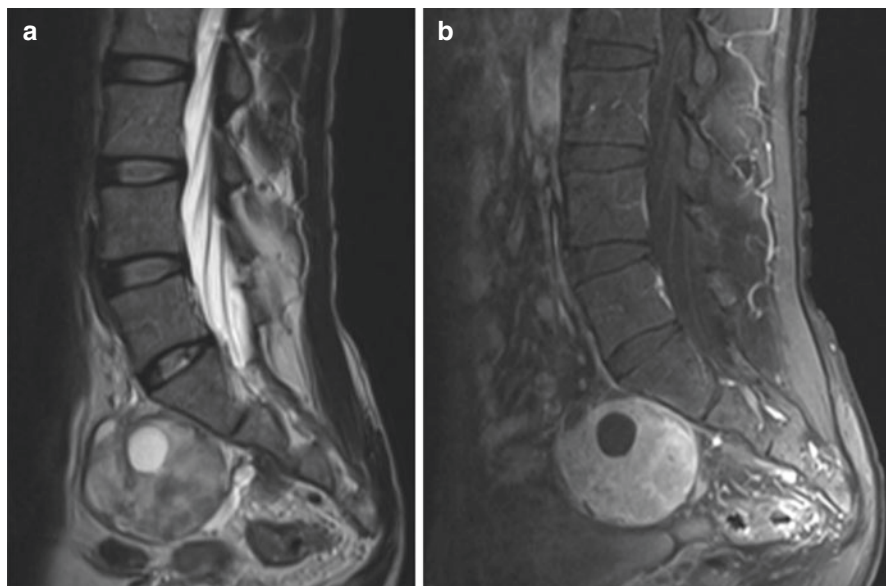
Imaging of a 44-year-old man with enlarging pre-sacral mass. (a) Sagittal T2 MRI demonstrating a T2 isointense and hyperintense, heterogenous pre-sacral mass that is partially cystic. (b) T1 with contrast administration demonstrates an avidly enhancing mass. CT-guided biopsy results suggested a giant schwannoma versus malignant peripheral nerve sheath tumor
